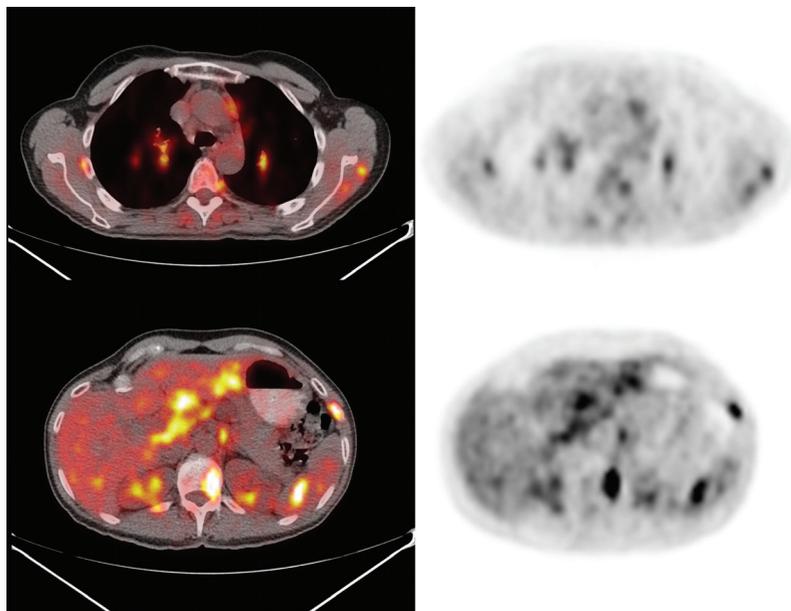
There was widespread adenopathy including left retromandibular, mediastinal, hilar, abdominal, retroperitoneal and inguinal nodes (largest mediastinal node measured 1.4 cm, and the most metabolically active was a right perihilar lymph node with SUV_{max} 5.2). The innumerable liver and spleen hypodensities identified on CT were intensely ^{18}F -FDG avid with SUV_{max} 4.3 in the liver and 5.9 in the spleen. No primary malignancy was identified, but findings were interpreted as highly concerning for disseminated metastatic disease. The patient remained asymptomatic. PET-guided bone marrow biopsy of the left posterior superior iliac spine revealed several non-necrotizing, well-formed granulomas. These granulomas were paratrabeular in distribution and were composed of tightly apposed epithelioid histiocytes, with occasional multinucleated giant cells, consistent with sarcoidosis.
